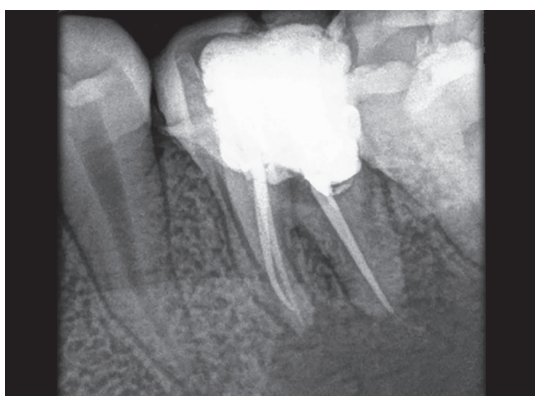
Radiograph showing obturation with 36
